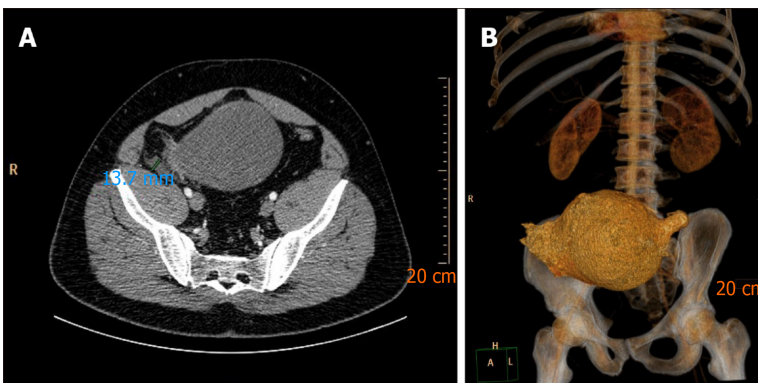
Computed tomography findings. A: Computed tomography (CT) scan showing voluminous cystic tumor communicating with the cecum; B: CT scan showing reconstruction image of the same lesion.
